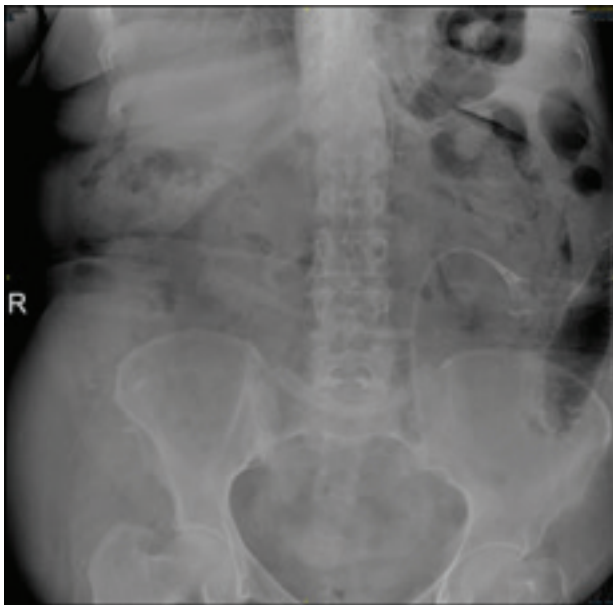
X-ray showing the broken re-entry Malecot nephrostomy tube
